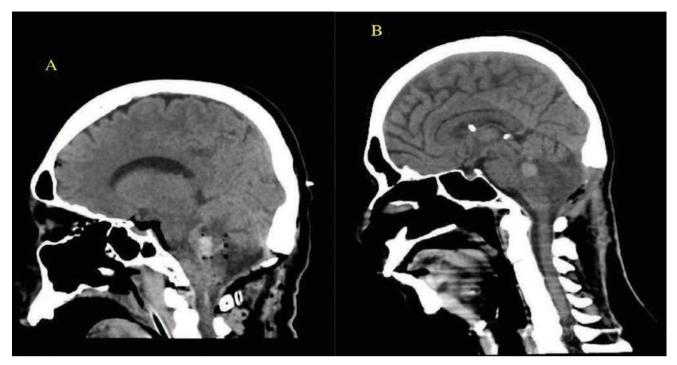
CT scan sagittal view showing (A) lobulated midline hyperdense mass in the posterior fossa mostly had been evacuated while (B) readmission CT scan revealed a hyperdense rounded nodule in surgical bed at the posterior fossa, suggested to be a recurrent mass lesion
